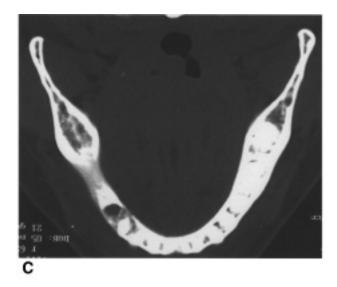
A. Clinical view of a periodontal fistula of the alveolar bone close to the first inferior premolar. B. The radiograph clearly shows a nonhealing socket 4 months after tooth extraction. C. Wider bone damage is shown by CT scan.
